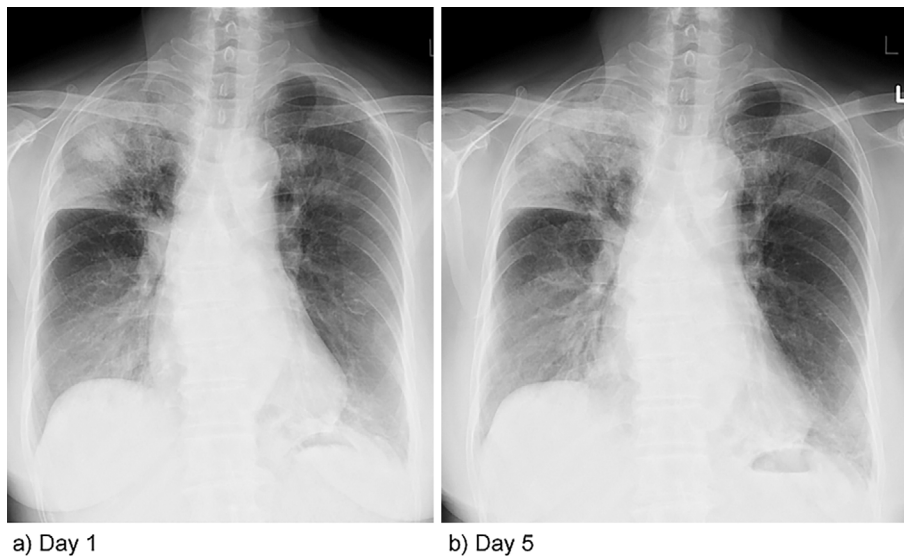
(a) Chest X-ray taken on Day 1 showing bilateral pulmonary infiltrates, especially in the right upper and right lower lung fields. (b) Chest X-ray taken on Day 5 showing progressive worsening of the pulmonary infiltrates, especially in the right upper and lower and left lower lung fields.
